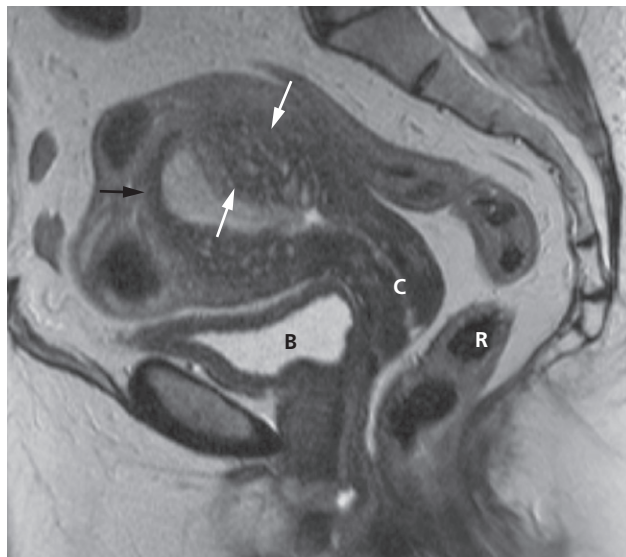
Adenomyosis. Sagittal T2-weighted MRI demonstrating a markedly widened junctional zone containing small cysts (between the white arrows). A normal section of junctional zone is seen in the region of the uterine fundus (black arrow). Two low signal intensity ovoid fibroids are also present in the fundus. B, bladder; C, cervix; R, rectum.
